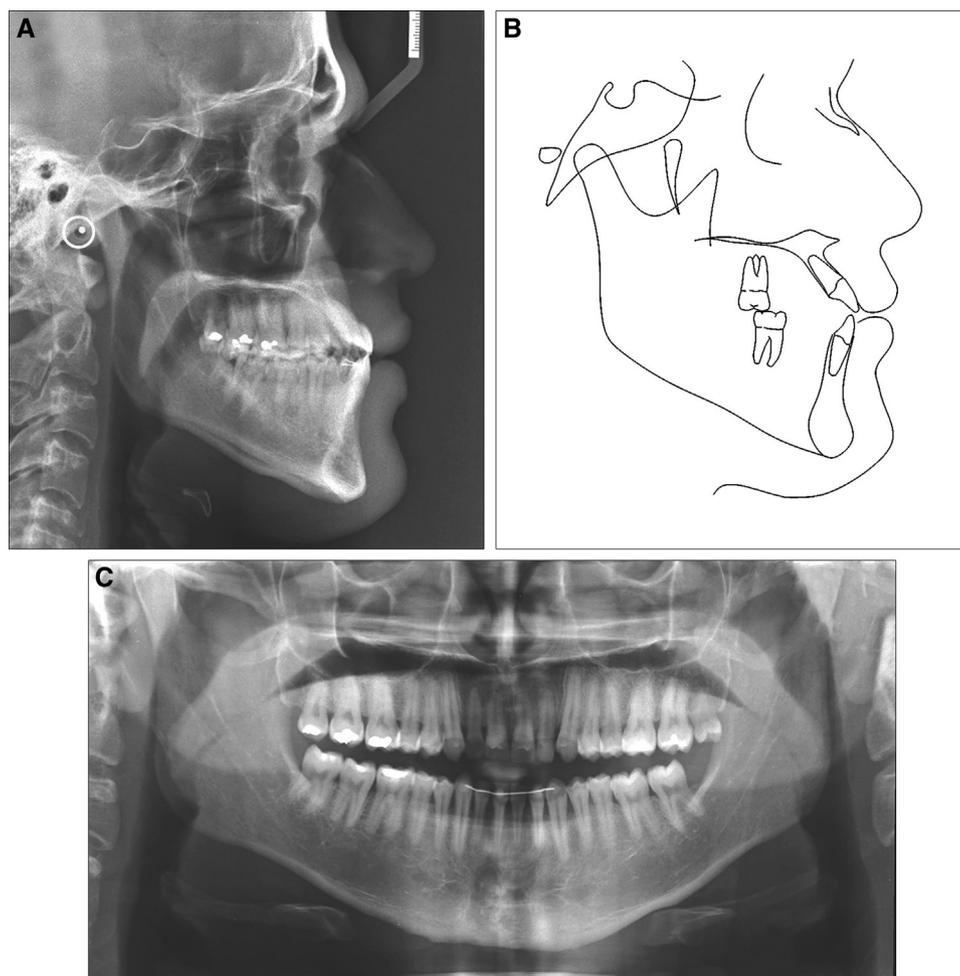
Pretreatment radiographs: A, cephalometric radiograph; B, cephalometric tracing; C, panoramic radiograph.
